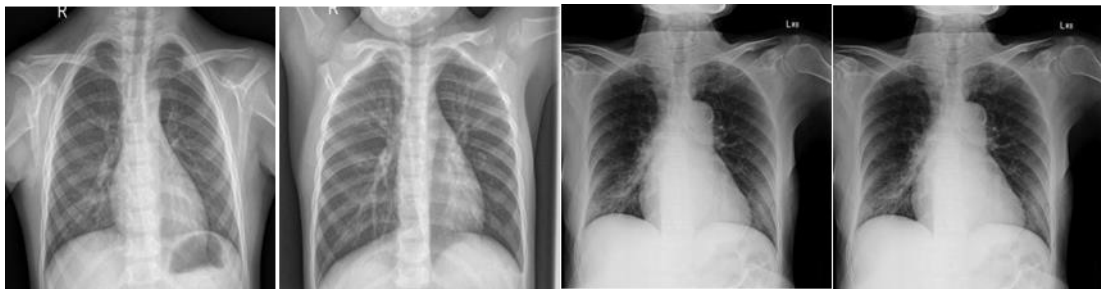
Normal X-ray images
